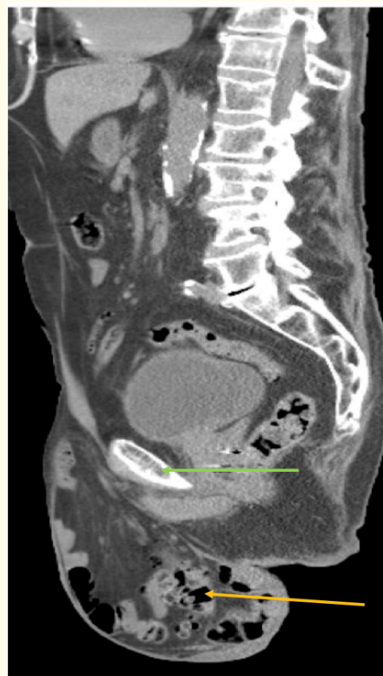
CT scan sagittal view showing the giant inguinal hernia (orange arrow) below the pubic bone (green arrow).
